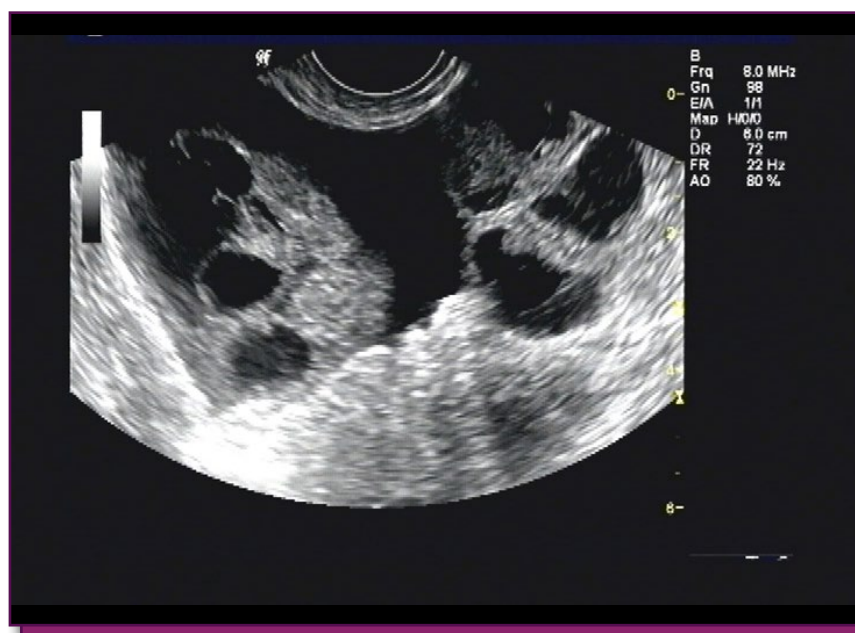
Ultrasonic evidence of Ascites
